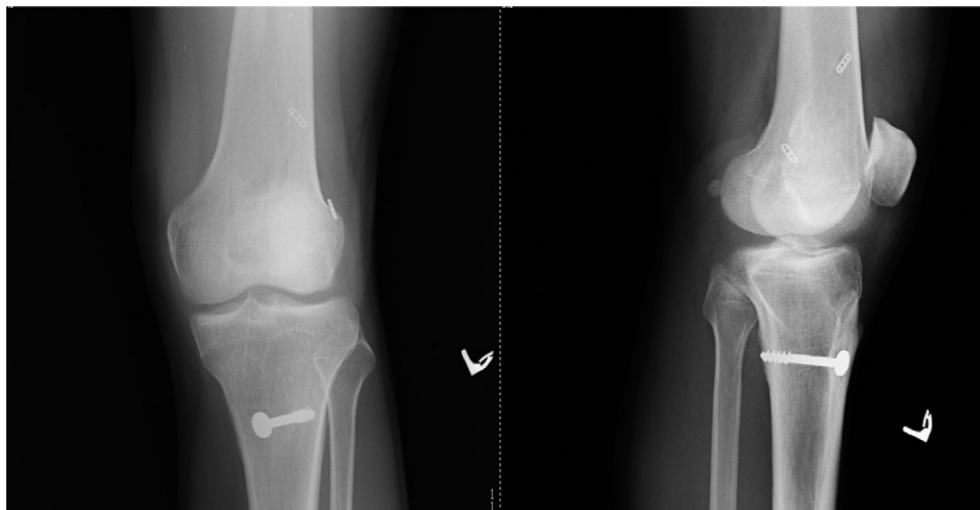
Postoperative X-ray film of the anteroposterior (AP) and lateral.
